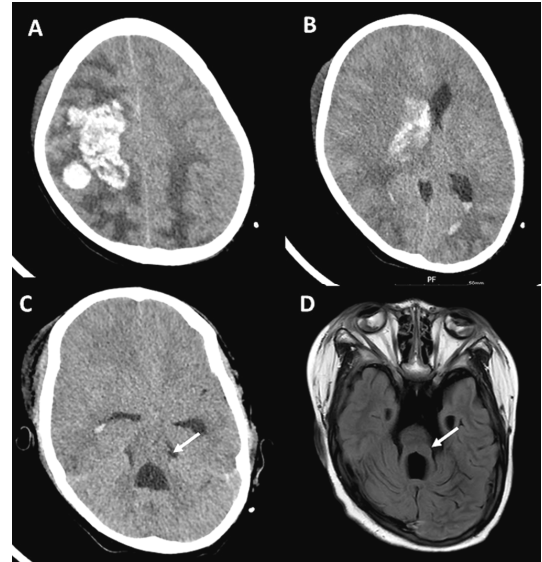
At 9 years 4 months of age, the patient underwent brain computed tomography (CT) that showed intracranial hemorrhage, intraventricular hemorrhage, and midline shifting to the left side due to hypertension (A and B). The molar tooth sign (MTS) was observed on brain CT performed at 9 years 4 months of age (C) and on brain magnetic resonance imaging (MRI) at 12 years 2 months of age (D). Axial T2-weighted MRI shows an MTS appearance of the midbrain with thickened superior cerebellar peduncle (arrow) and vermian hypoplasia.
